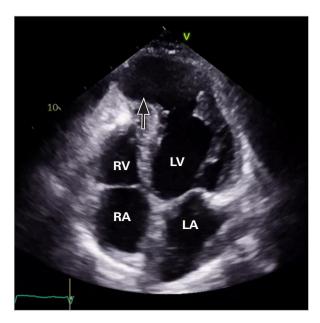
Repeat apical 4-chamber transthoracic echocardiogram without UEA shows a large apical pseudoaneurysm (arrow) that measured 10.6×9.2 cm, 5 months after the index admission. The 2 prior thrombi had resolved but were also not visualized using UEA (thus not shown).
